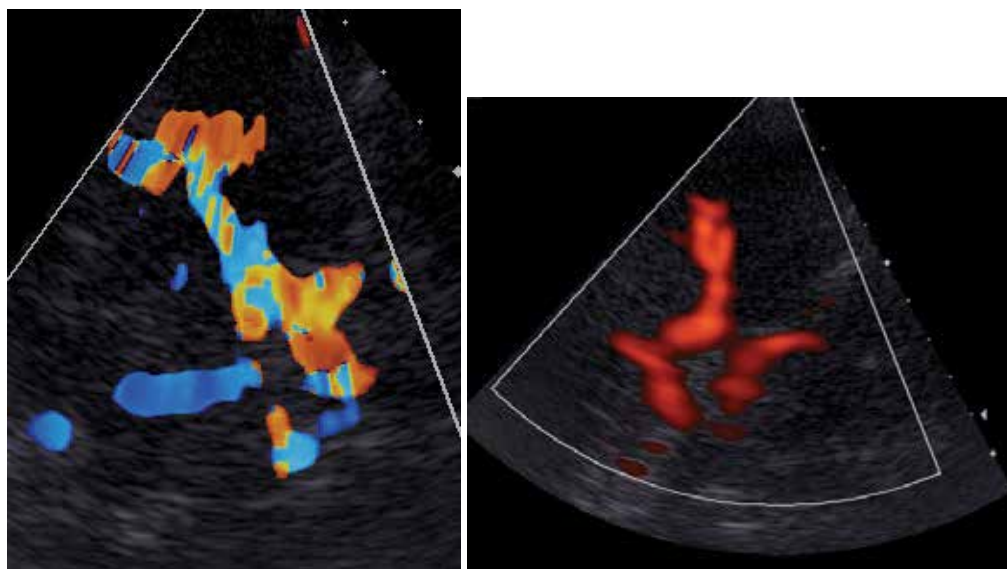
M1 segment using color-Doppler (a) and power-Doppler (b)
